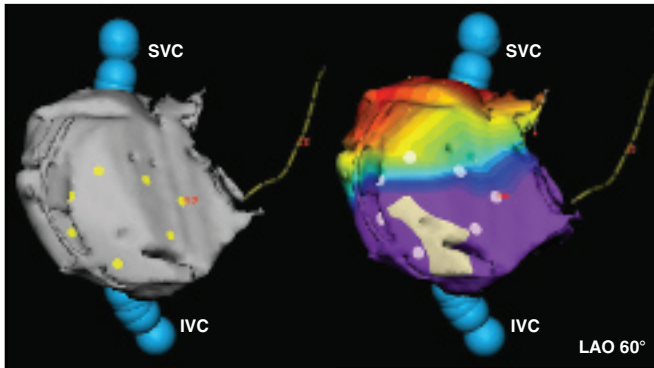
Patient presented for ablation with an atrial macroreentrant tachycardia. Complete integration of a pre-acquired 3D CT image (NavX fusion algorithm) of the right atrium was used for anatomical orientation. No anatomical surface reconstruction was performed. Registration, alignment, and integration of the CT scan was achieved solely through seven landmark points at the tricuspid annulus, one landmark point in the inferior isthmus, one landmark point in the fossa ovalis, and one landmark point in the right atrial appendage. Superior caval vein (SVC) and inferior caval vein (IVC) were marked through anatomical 3D points. The registered CT was the basis for 3D navigation and orientation. At different points within the right atrium, entrainment mapping was performed. The time difference between the post-pacing-interval and the tachycardia cycle length (= return cycle) was color-coded and projected onto the CT surface. Red areas indicate points with a short return cycle, therefore, being close to the reentrant circuit. Three-dimensional distributions of the entrainment properties reveal a reentrant circuit around the superior caval vein (= upper loop reentry). Placement of an ablation line between the superior tricuspid annulus and the SVC terminated the tachycardia and left the patient noninducible. The incisions on the CT surface (especially in the PA projection) resulted from artefacts within the CT scan caused by the leads of a dual chamber ICD.
